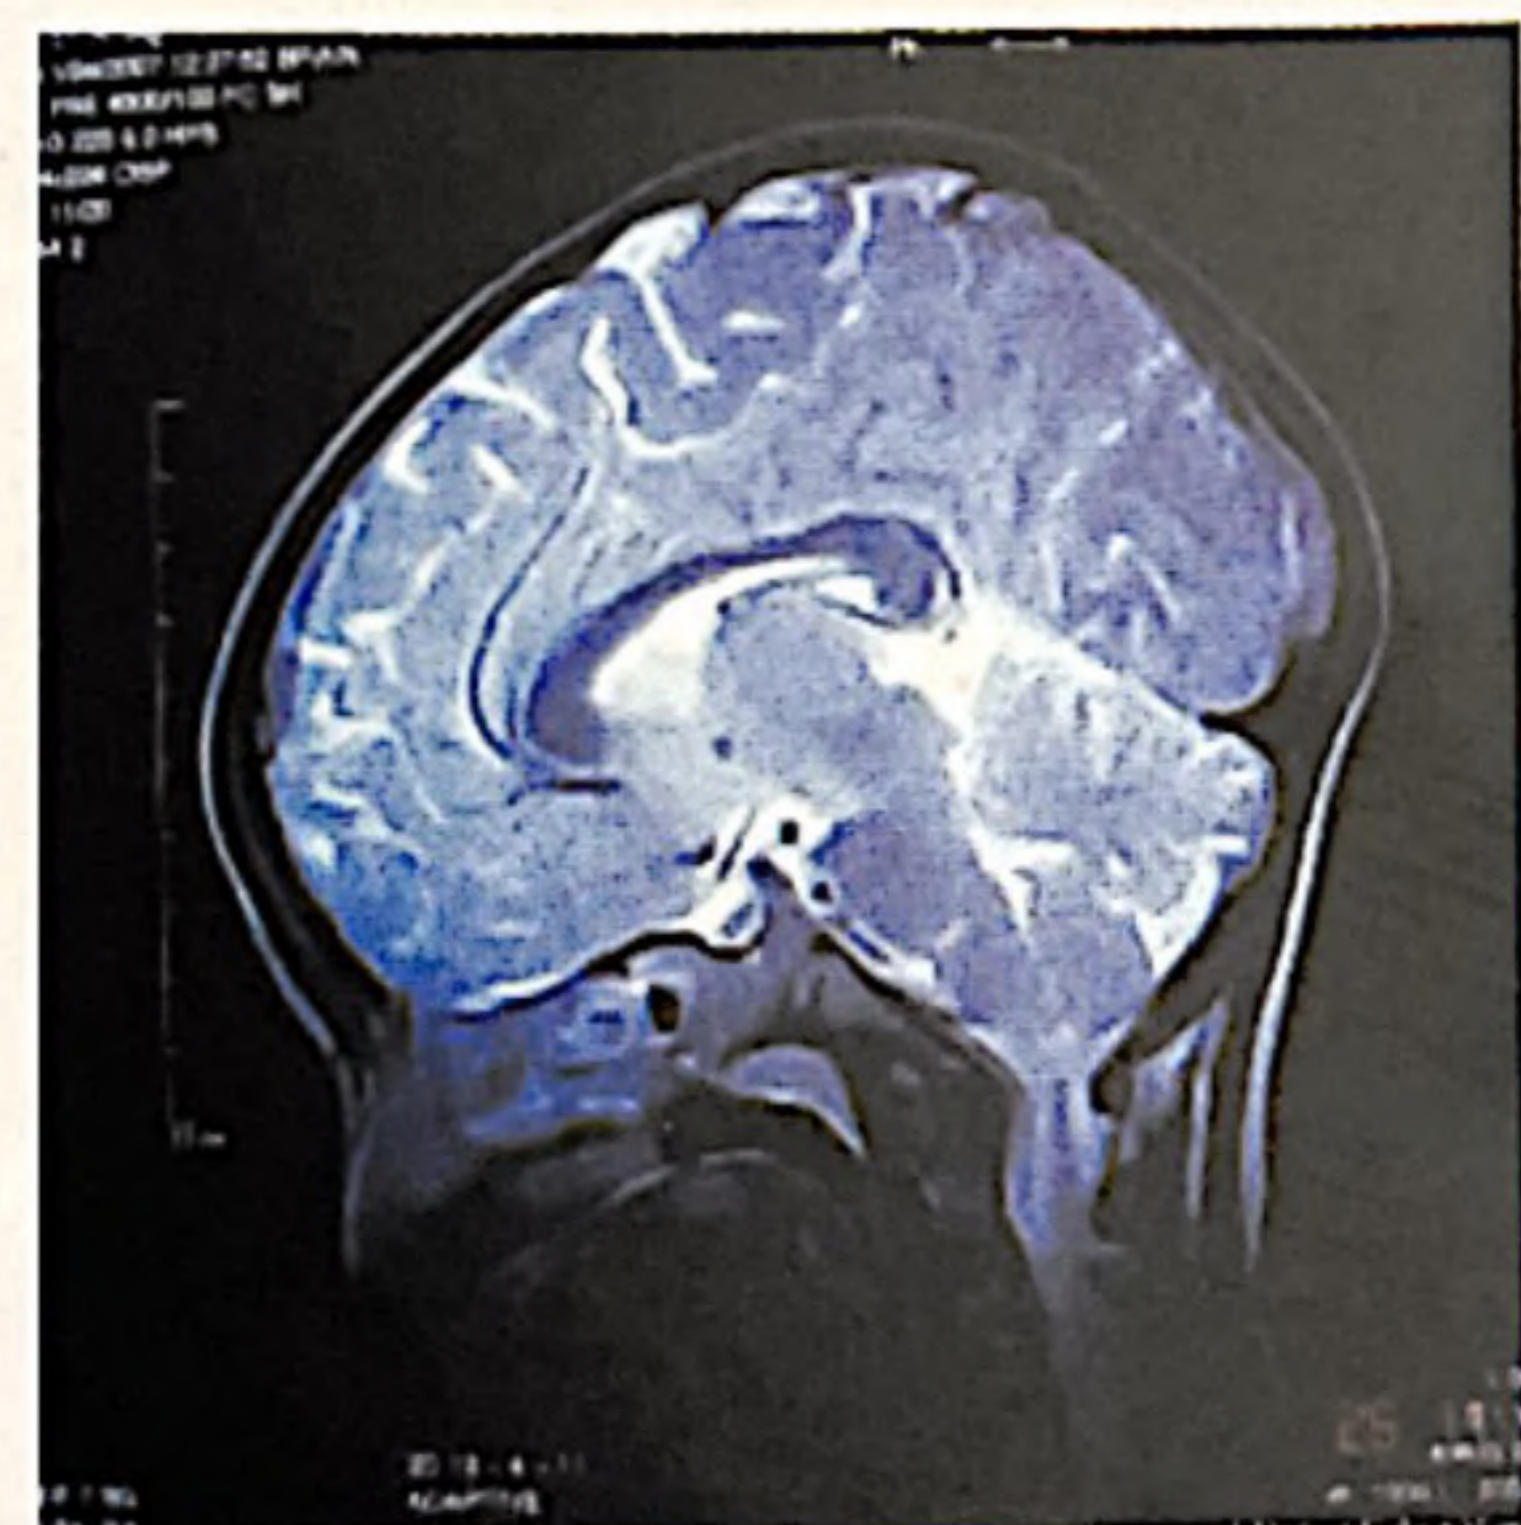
MRI of brain in sagittal view of T2 image showed enlarged pituitary gland (8.8x8.6 mm).
